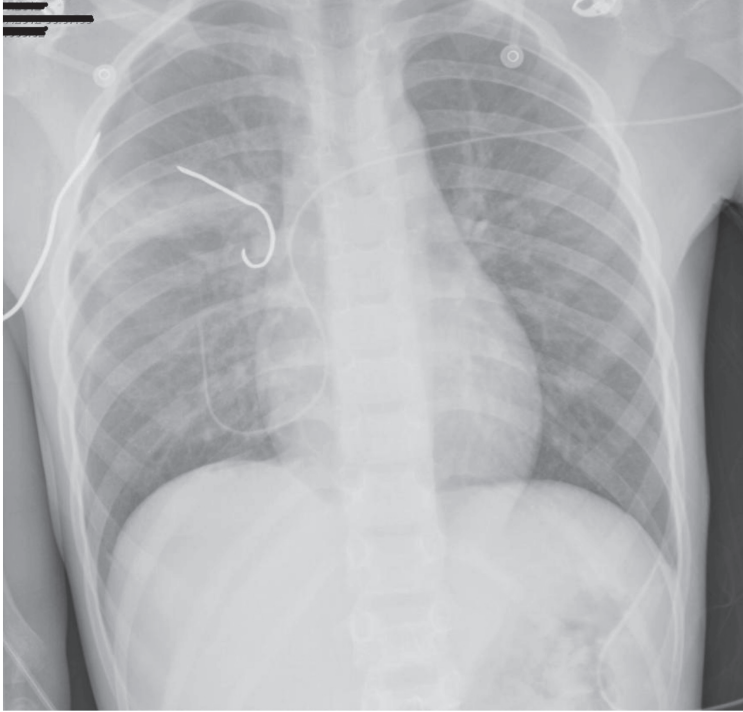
Chest radiograph with "shrapnel" in the patient right hemithorax.
